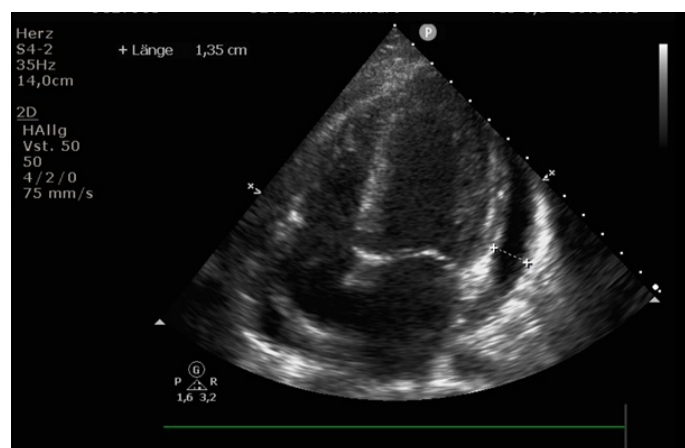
Transthoracic echocardiogram performed on day +19 after allogeneic SCT due to novel hypotension and tachycardia showed pericardial effusion with a diameter of ca. 1 cm
